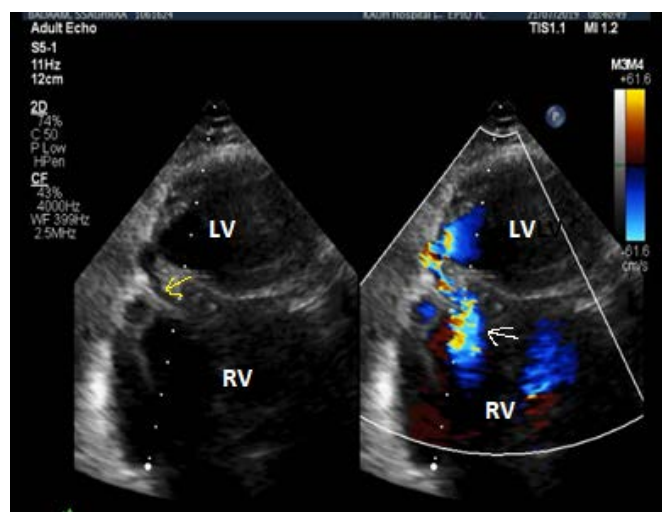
Preoperative transthoracic ECHO revealed antero-apical VSR diagnosed by left to right shunt (white arrow) in doppler mode and loss of septal integrity in M mode (yellow arrow). LV: left ventricle, RV: right ventricle.
